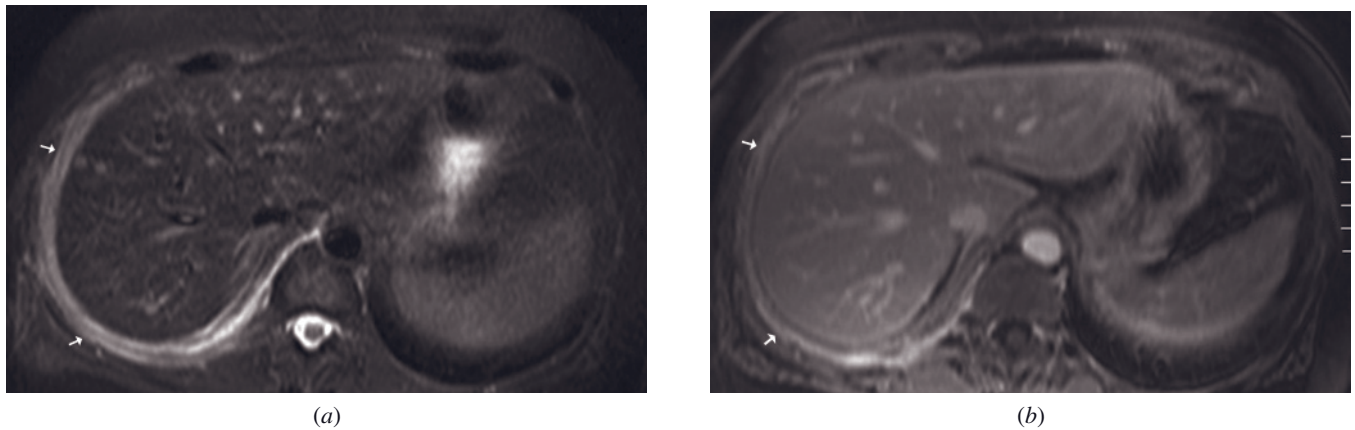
Pleural metastases. T2-weighted fat-suppressed ETSE (a) and postgadolinium 3D-GRE (b) images show enhancement and thickening of the pleura consistent with pleural metastases (arrows, a, b).
